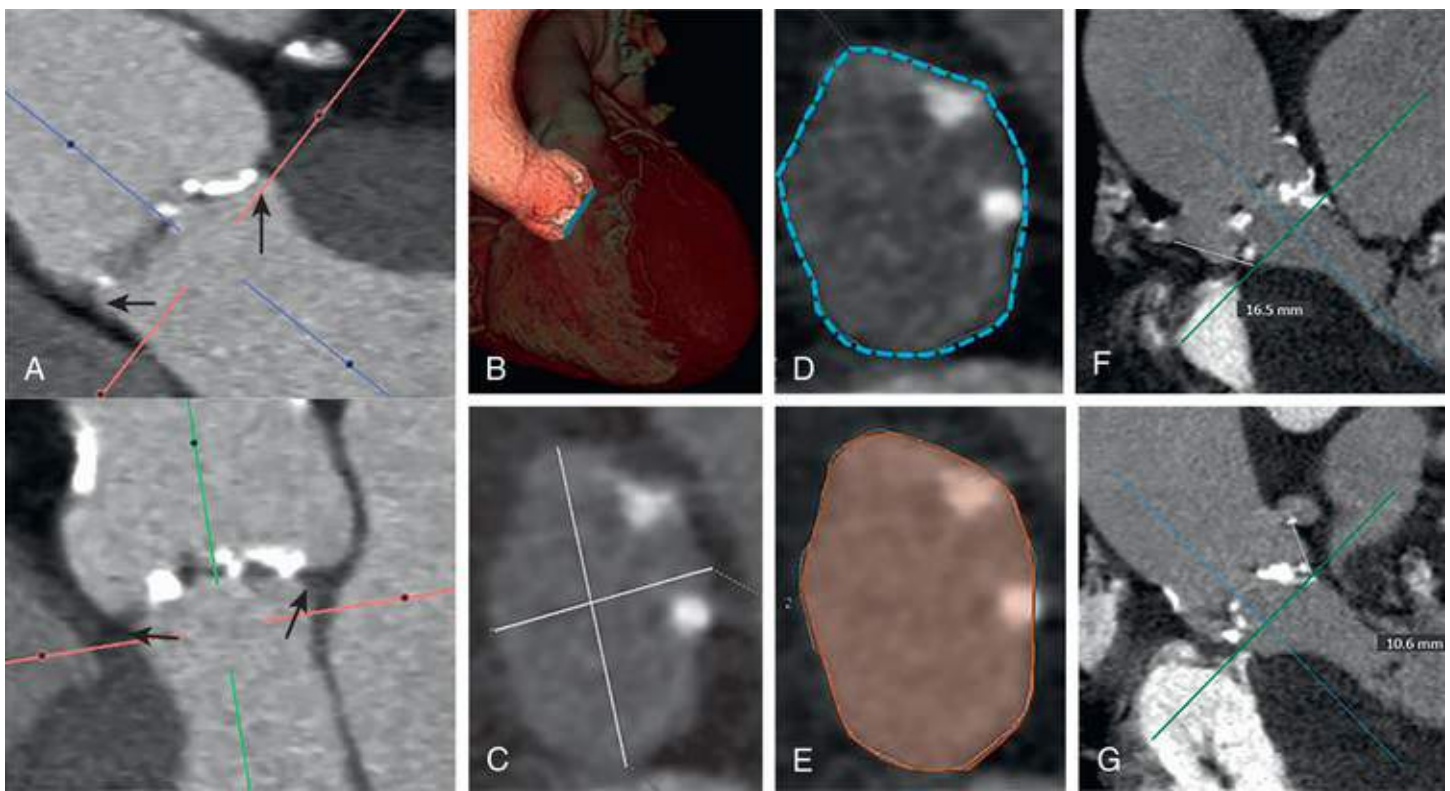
Cardiovascular CT for preprocedural planning of transcatheter aortic valve replacement (TAVR). A, Double-oblique approach to identifying aortic annular plane before TAVR (*black arrows*). Aortic annuli should be measured at the leaflet insertions rather than in the valve plane. B, Volume-rendered imaging of the aorta, aortic annulus, and aortic valve. *Blue line* indicates the plane of the aortic annulus. When all points in the aortic annular plane are aligned (as indicated by *blue line*), these CT projection angles can be helpful to proceduralists as a guide to which angles may be useful at the time of the TAVR procedure. Diameter (C), area (D), and, perimeter (E) measurements of the aortic annulus for proper sizing of the TAVR prostheses. Measurement of the right coronary ostial height (F), and left coronary ostial height (G), to ensure that the TAVR will not occlude the coronary ostia.
